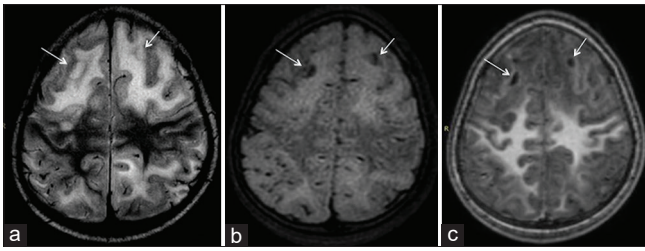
Magnetic resonance imaging of the brain in the patient showing extensive white matter hyperintensities (T2WI and FLAIR) with cystic changes (T1WI) in the frontal lobes (arrows)
